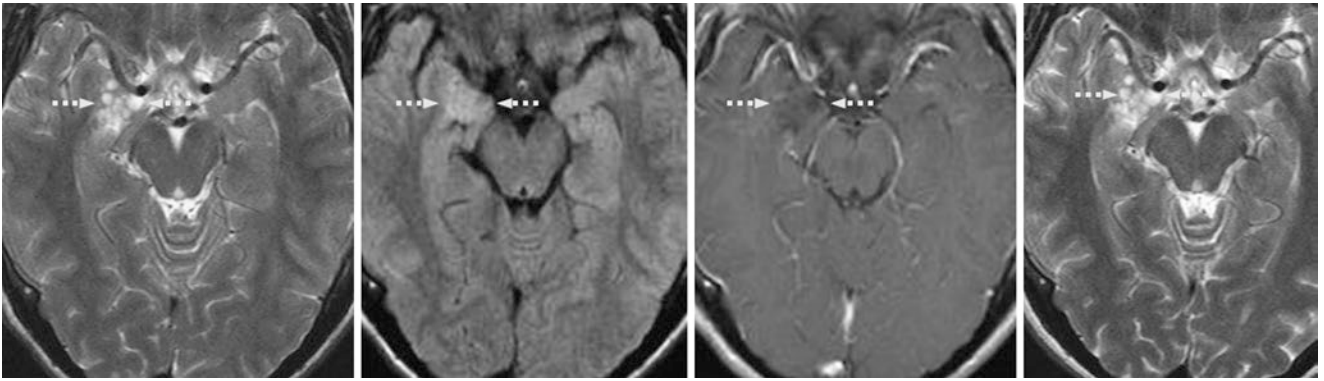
Comparison case of cystic ganglioglioma. A 26 year old with seizures had a right medial temporal lobe mass that appeared multicystic on a 1.5 T MRI with axial T2WI (*left*); however, the lesion was entirely
